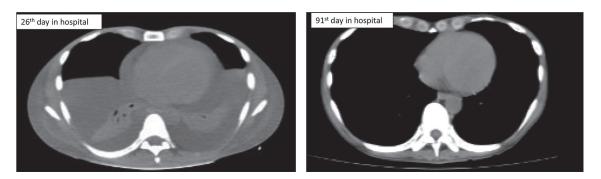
Clinical course of pleural and pericardial effusion (CT scans at the heart level)
